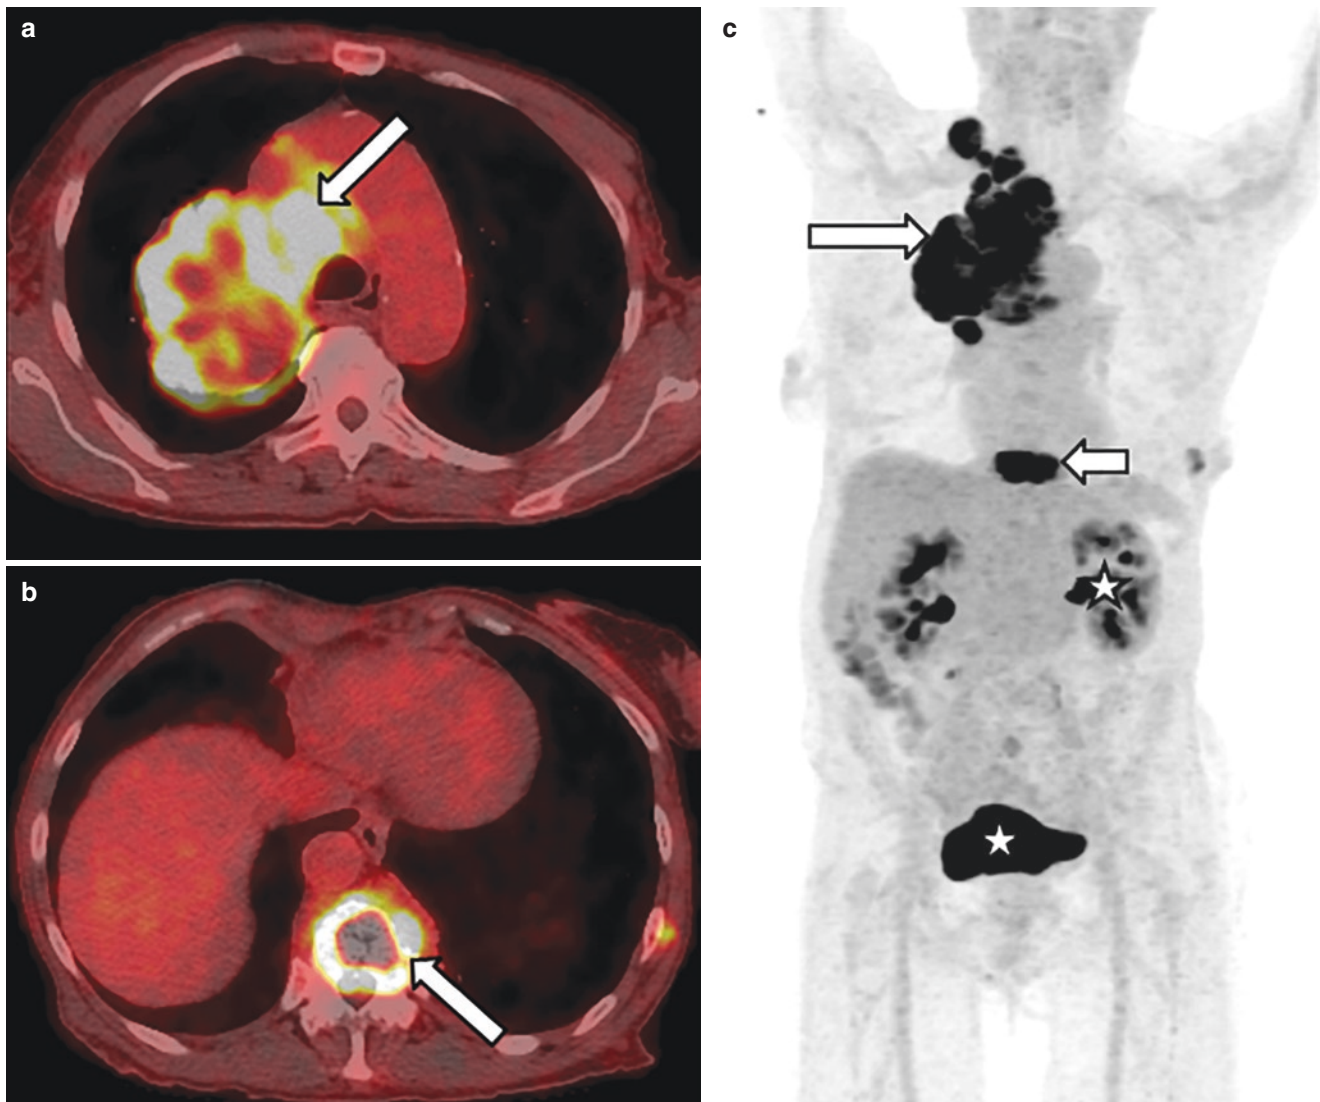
Case Study.* Imaging at follow-up patient encounter, 1 year later (a–c). Bright hot iron (yellow/white) color in axial fused FDG-PET/CT image indicates increased glucose (FDG) uptake in the highly metabolically active primary right hilar/right upper lobe malignancy. Bright hot iron color in (b) indicates metastatic lesion in the T12 vertebral body. Full-body three-dimensional FDG-PET projection in (c)
